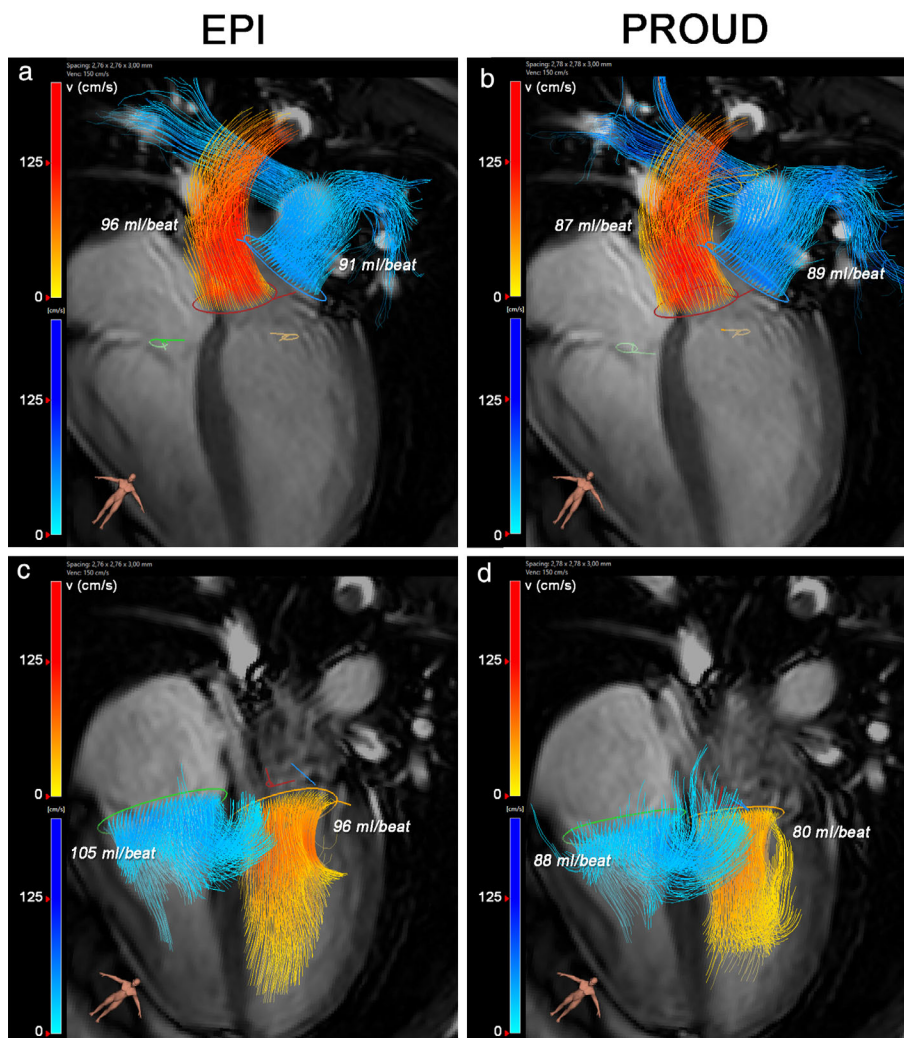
EPI and PROUD 4D flow MRI streamline visualizations of blood flow through the aortic valve (a, b, orange), pulmonary valve (a, b, blue), mitral valve (c, d, orange), and tricuspid valve (c, d, blue) in a 31-year-old healthy subject, resulting from semiautomated retrospective valve tracking. Measured flow volumes across the valves are listed in the figure. Valve tracking was performed on bSSFP cine images on two orthogonal views for each heart valve. Four-chamber bSSFP view is visible in the background.
